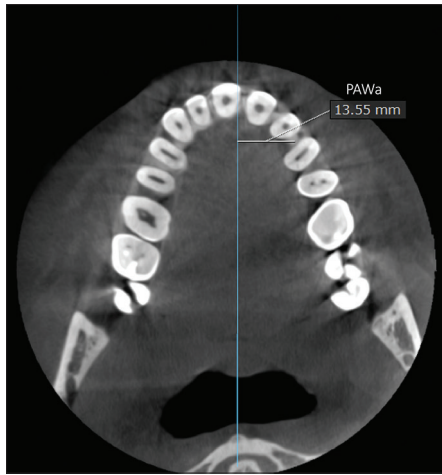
CBCT axial section at the level of the alveolar crest mesial to the first premolar. Maxillary first premolar alveolar width (PAWa) measured in the axial section from the alveolar crest mesial to the first premolar at the impacted side to the midline. A similar method was utilized for the non-impacted side. Vertical line = the midline, a line from ANS to PNS (ANS = primary reference)
